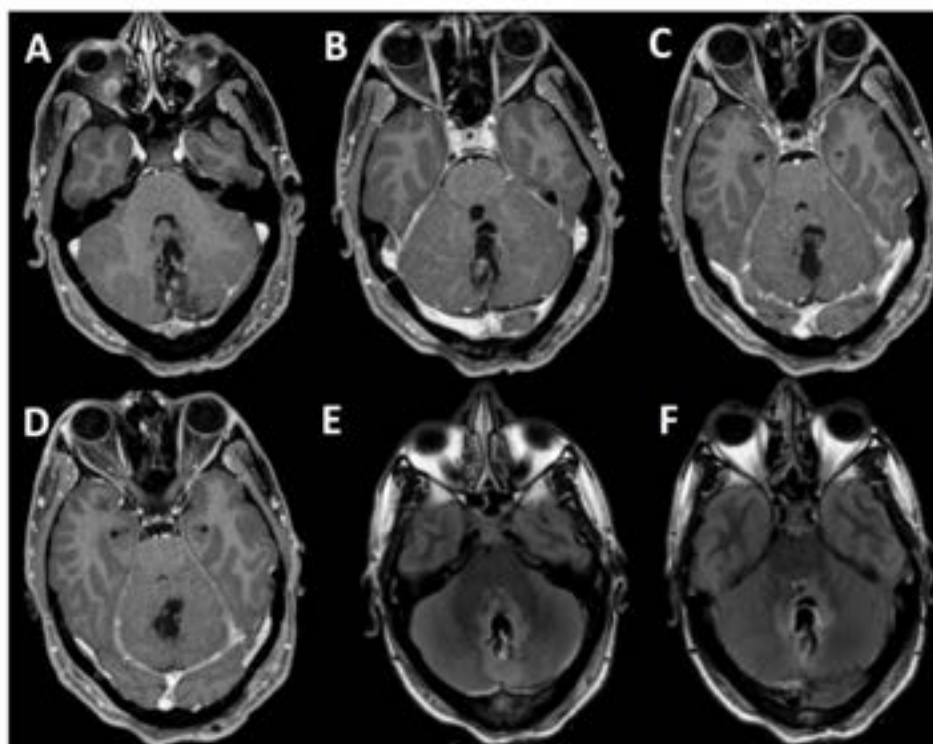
T1-weighted MRI of the skull with gadolinium, with axial sections A, B, and C. Expansive, extraventricular, infiltrative lesion in the cerebellar vermis, measuring approximately 3.5 x 2.4 x 2.4 cm. D, E, and F. Sagittal lesion that is expansive and located within the cerebellum. This lesion exerts pressure on the fourth ventricle, resulting in supratentorial hydrocephalus.
